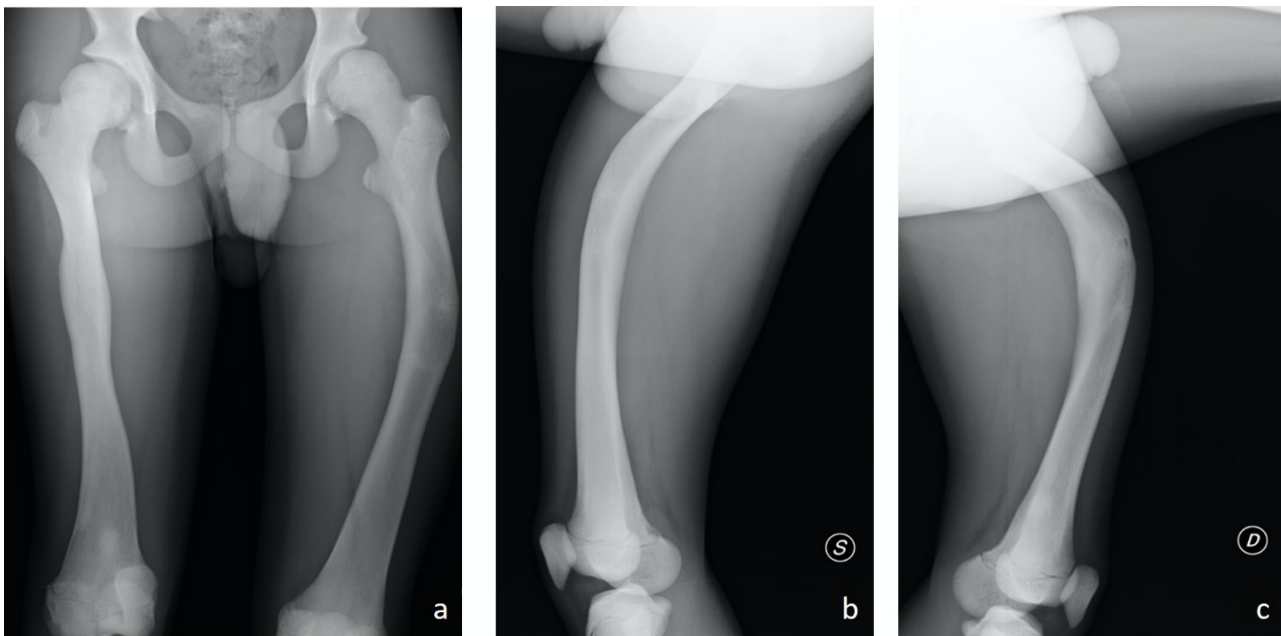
a) Anteroposterior X-ray of the pelvis and the femurs showing alterations of the acetabular development, femoral deformities and signs of previous fractures; b) Lateral radiograph view of left femur; c) Lateral radiograph view of right femur.
